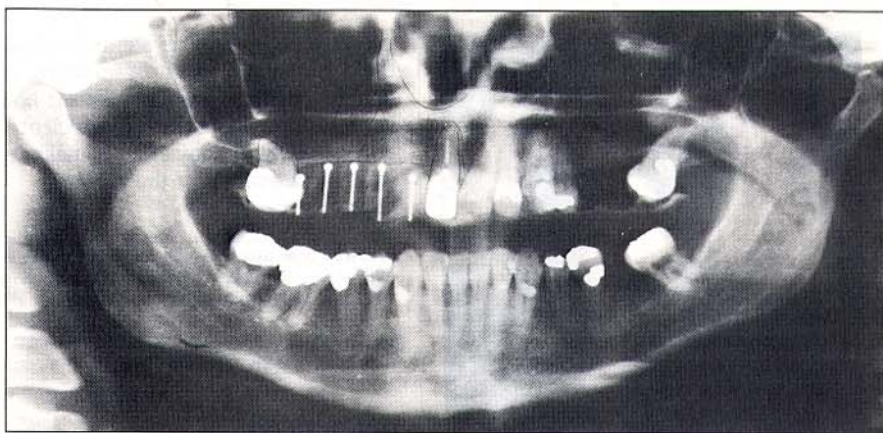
Panoramic radiograph of the appliance (as seen in Fig. 5) taken after securely seating it in the patient's mouth. With this appliance and radiograph, the surgical specialist can accurately relate any location on the osseous crest with the radiographically available bone height. This in turn allows the more precise selection of proper implant lengths and mesio-distal positioning.
